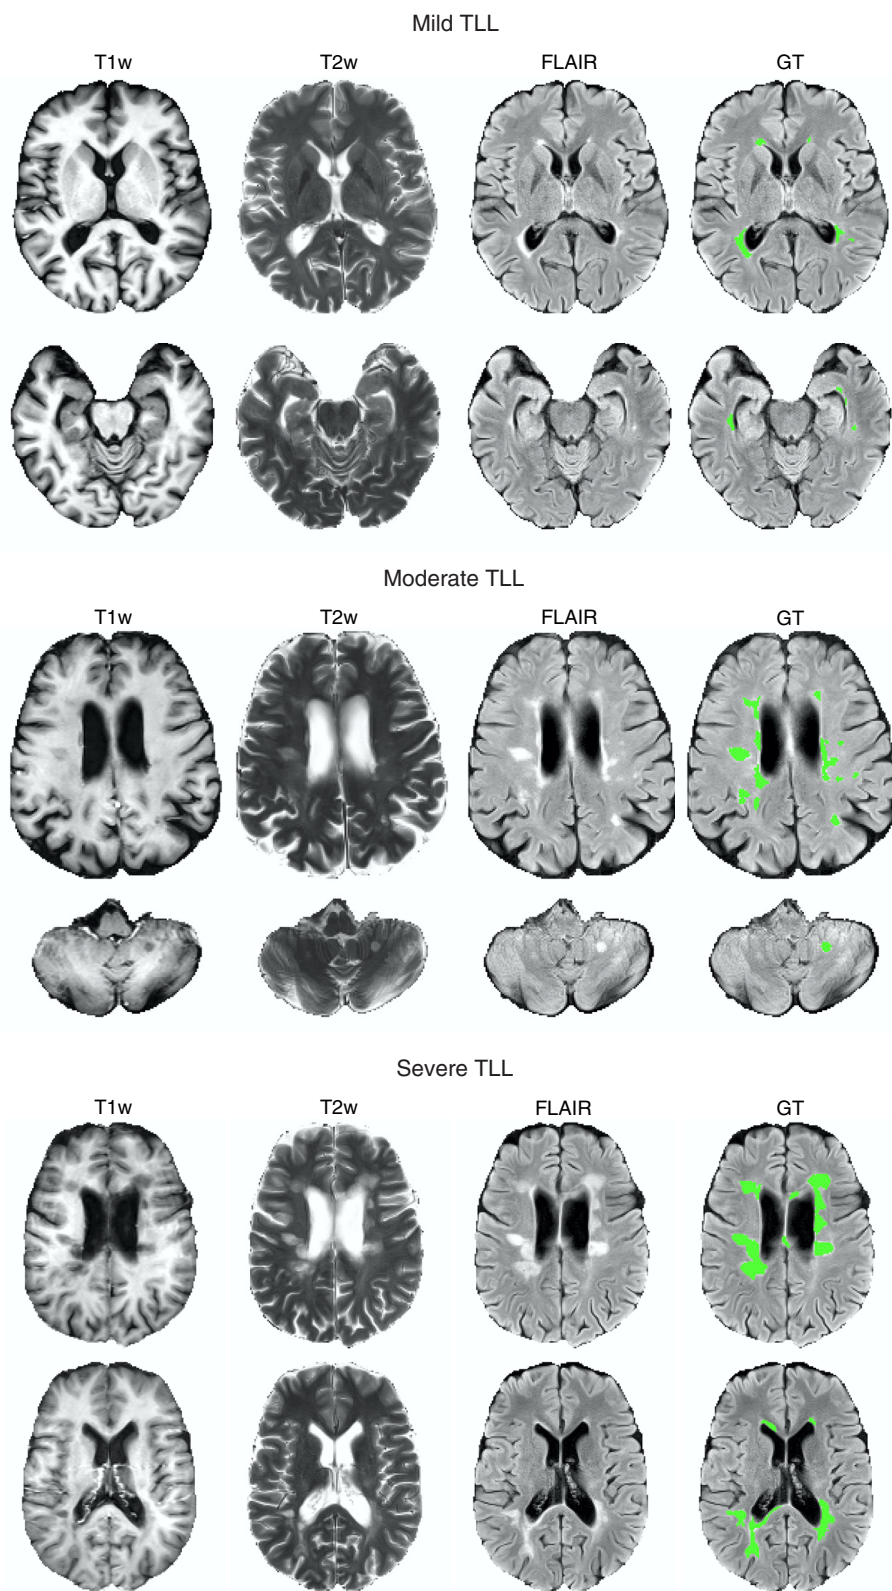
MR images and the reference segmentations of three patients with mild, moderate, and severe TLLs.
